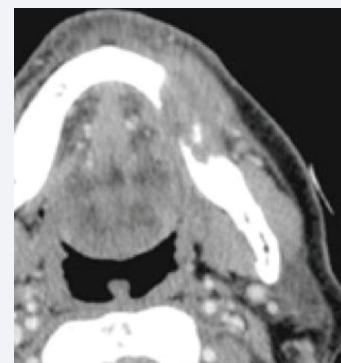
CT of the Head and Neck Showing Bone Erosion
